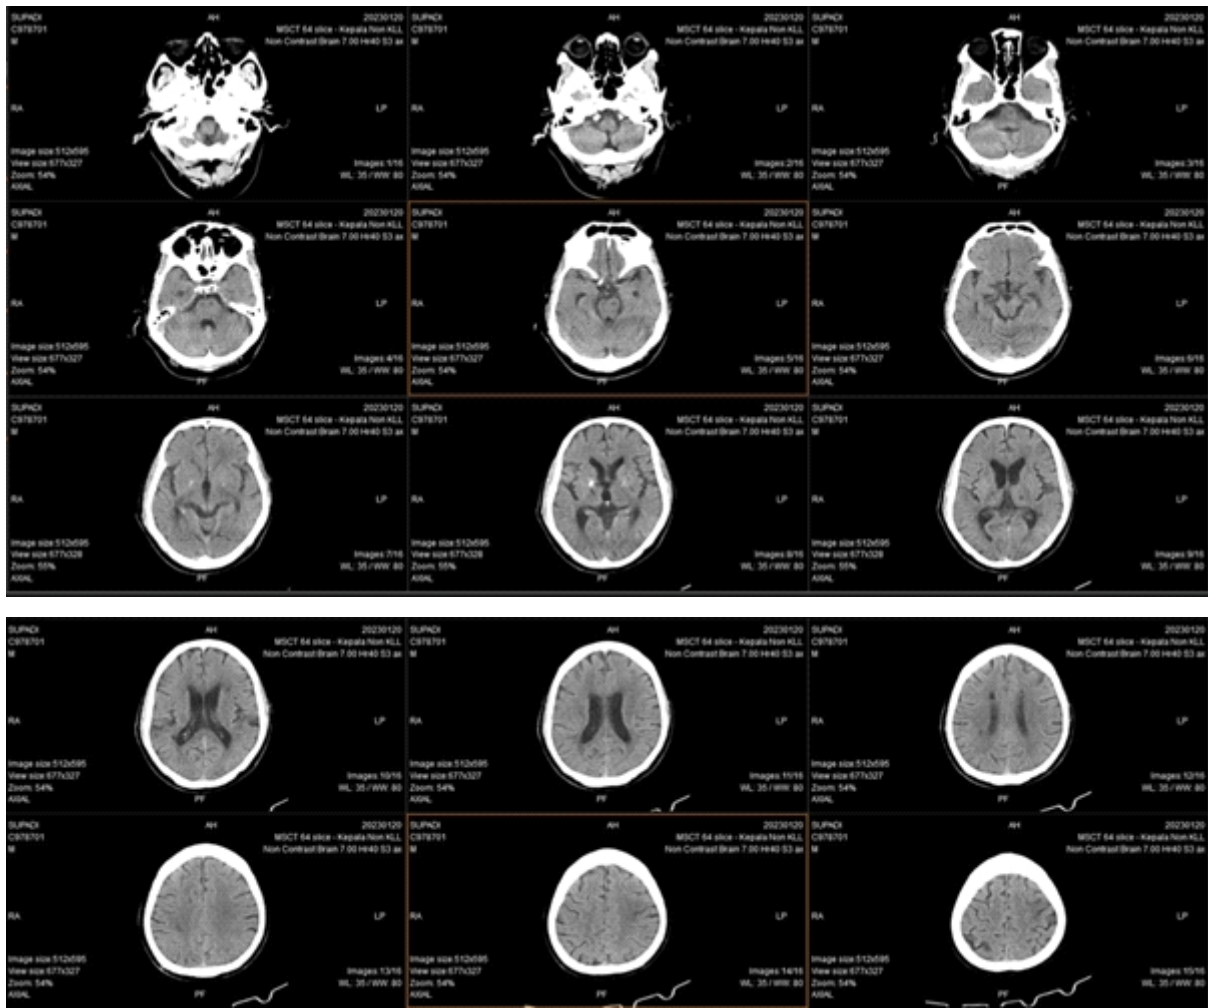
Non-Contrast Head CT Scan from the patient
